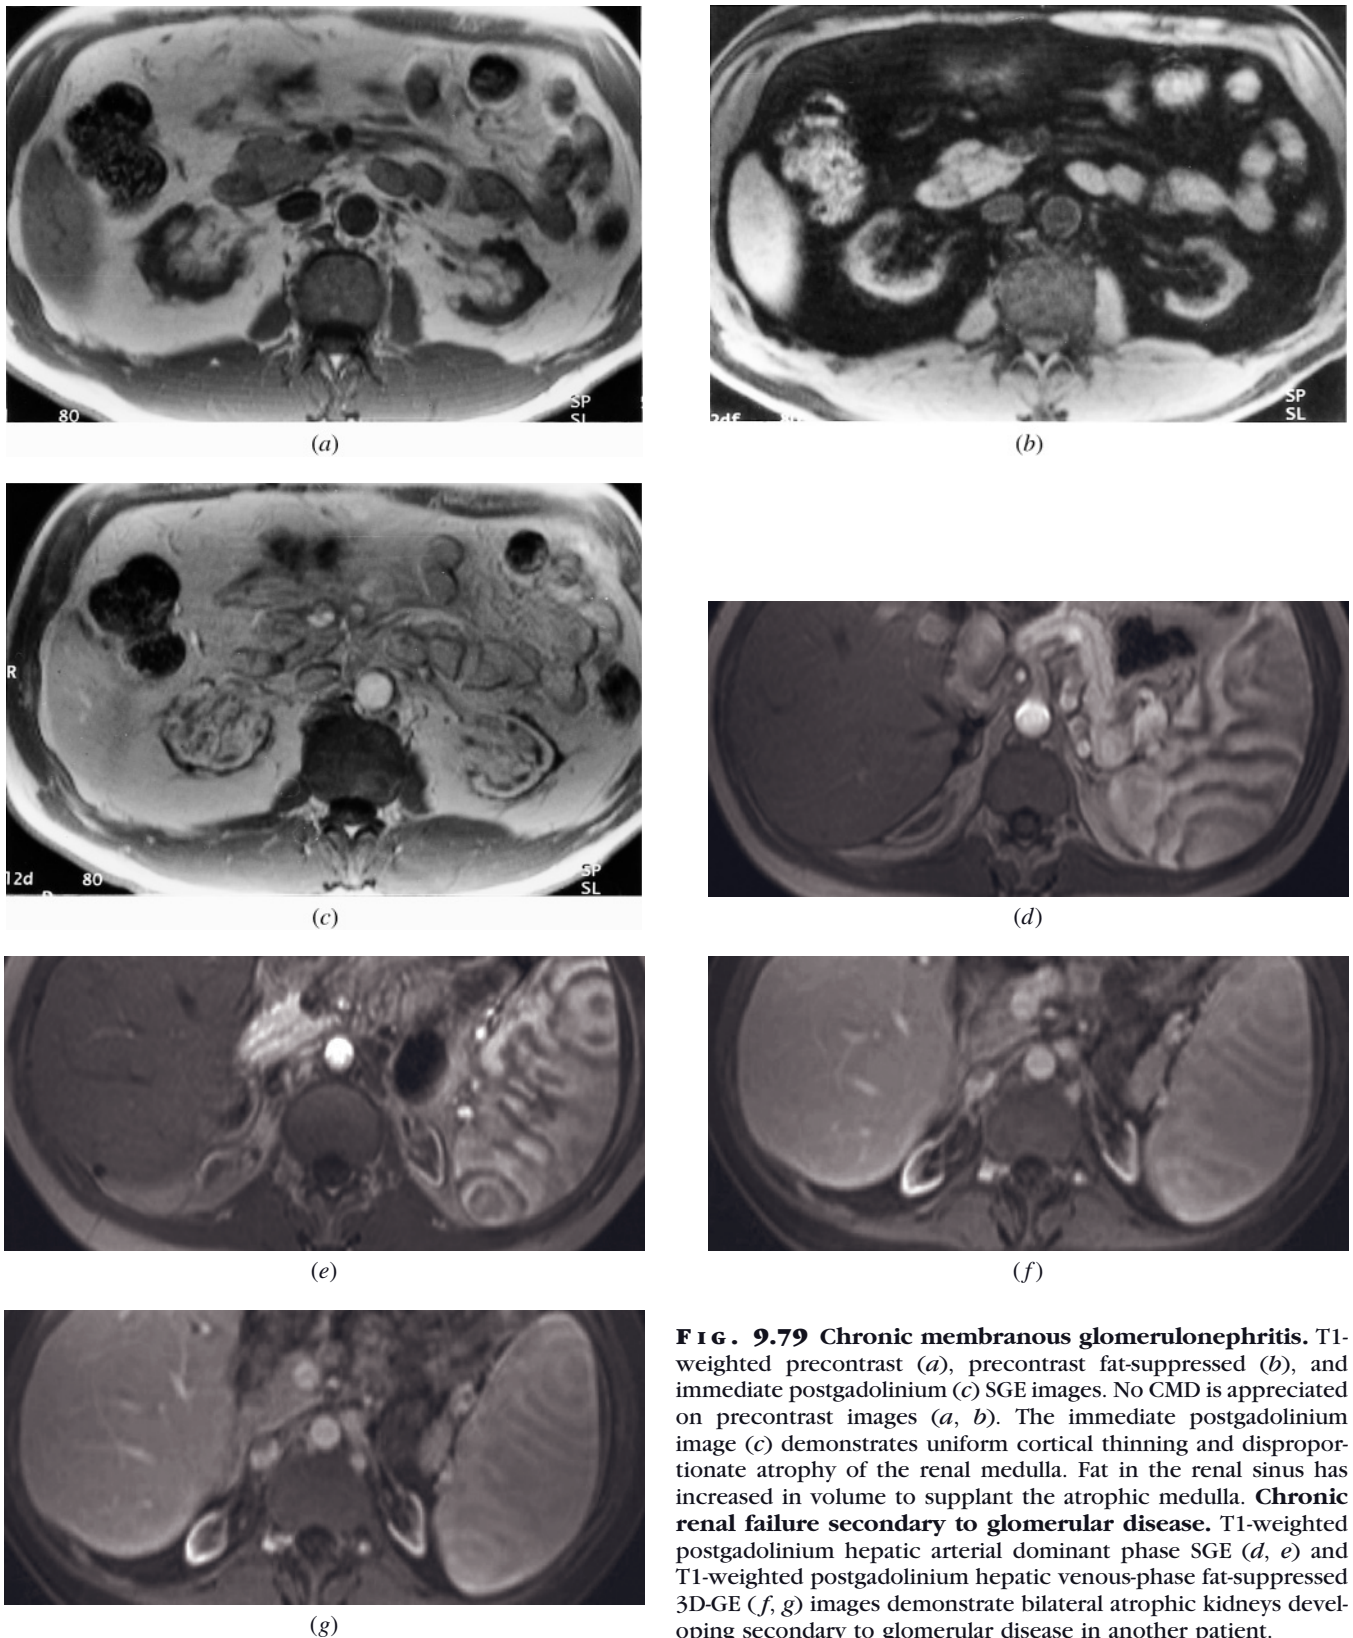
Chronic membranous glomerulonephritis. T1-weighted precontrast (*a*), precontrast fat-suppressed (*b*), and immediate postgadolinium (*c*) SGE images. No CMD is appreciated on precontrast images (*a*, *b*). The immediate postgadolinium image (*c*) demonstrates uniform cortical thinning and disproportionate atrophy of the renal medulla. Fat in the renal sinus has increased in volume to supplant the atrophic medulla. Chronic renal failure secondary to glomerular disease. T1-weighted postgadolinium hepatic arterial dominant phase SGE (*d*, *e*) and T1-weighted postgadolinium hepatic venous-phase fat-suppressed 3D-GE (*f*, *g*) images demonstrate bilateral atrophic kidneys developing secondary to glomerular disease in another patient.
